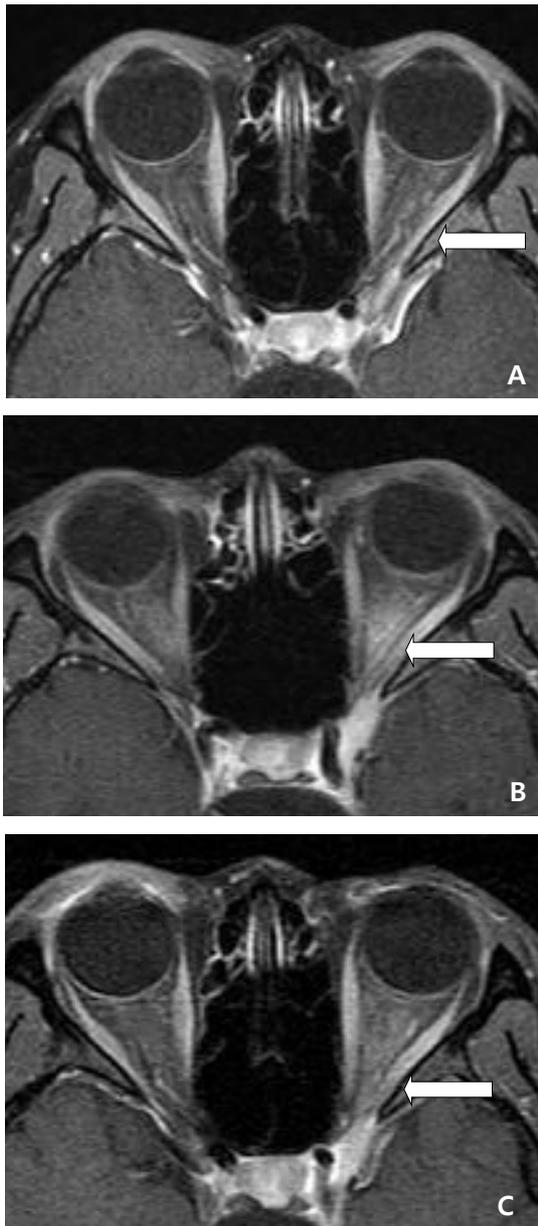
Orbital MR images. (A): 10 days after the onset of ocular pain and headache, initial T1-weighted MR images shows normal superior rectus muscle or orbital structures. (arrow) (B): 40 days after onset of symptom, T1-weighted MR images of the left superior rectus muscle shows more enhanced findings than previous images. (arrow) (C) 1 months after steroid therapy, follow-up MR images shows reduced signals. (arrow)
